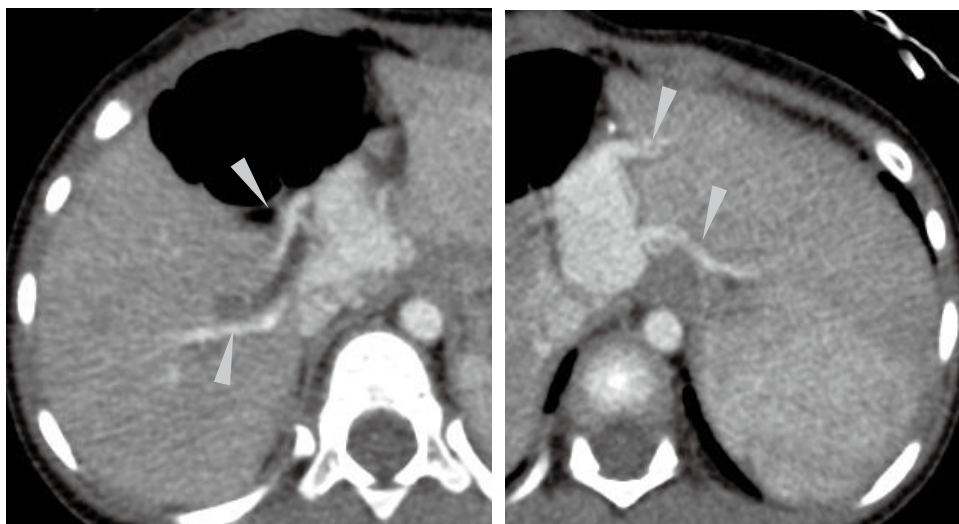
Postoperative abdominal enhanced CT showing the intrahepatic portal vein is clearly visualised.
